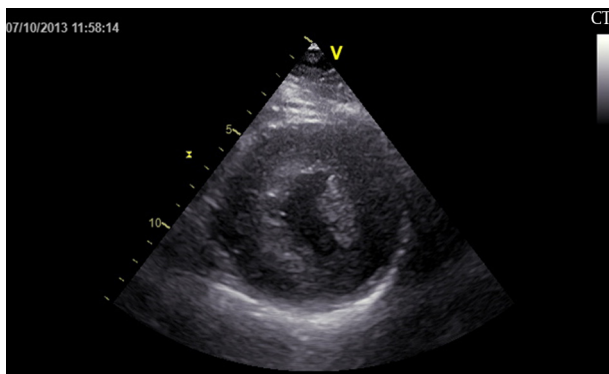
Hypertrophy and the Abnormal Position of the Lateral Papillary Muscles in the Parasternal Short-Axis View
